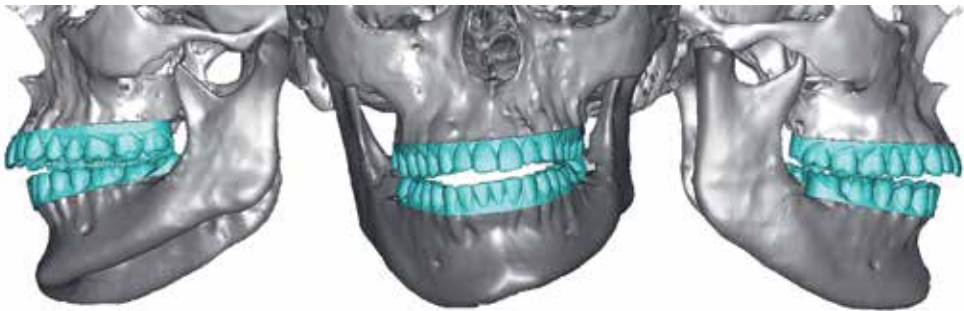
Process of CBCT cleaning and fusion with intraoral surface scan data.
